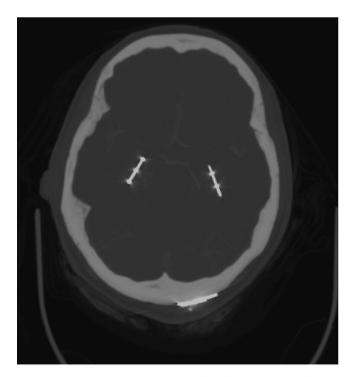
CT brain status post RNS showing bilateral hippocampal lead implantation via occipito-temporal trajectories. arose unilaterally, solely from the right side [Fig. 2]. Review of the data acquired from the contralateral (left) lead showed independent interictal activity, but no clear ictal activity or seizure detections were captured in that lead. The primary team felt that the activity recorded bilaterally using sEEG did not reflect the patient's habitual seizures, given that the patient was stimulated, sleep deprived, and in a stressful environment while in the hospital. By contrast, the RNS was particularly useful in providing a real life perspective of the patient's seizure burden and origin. The left-sided interictal discharges were therefore attributed potentially to secondary epileptogenesis, via a kindling-like process, with her primary epileptogenic zone being the right sided mesial temporal lobe. RNS detection parameters were tuned, and the stimulation program was set at post op month 7 to deliver up to 5 100-milli-second burst treatments with frequency of 200 Hz and current of 0.5 mA upon a detection. Stimulation was turned on for 4 months before the next intervention. During this period, the patient was noted to have decreased intensity of her seizures, with elimination of her olfactory auras and post ictal states, though the frequency of seizures had not clearly changed.
